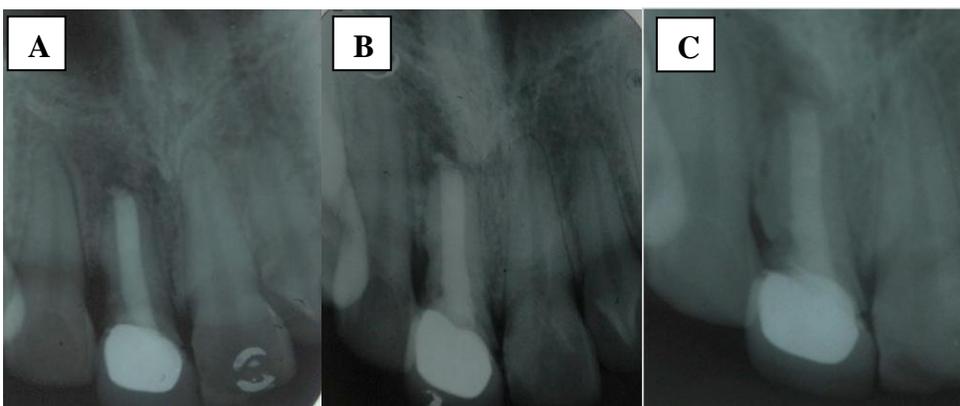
(A) Post-operative Radiograph.
